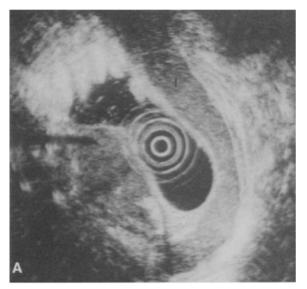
(A) Endosonogram reveals a hypoechoic submucosal wall infiltration (t) in the fundus of the stomach, which shows a continuity with a hypoechoic pancreatic tail tumor. The gastric wall adjacent to the liver (l) and spleen (s) shows no abnormalities (big arrows) in contrast to those of infiltrated area. Note the position of the needle as a echogenic spot (n) with dorsal shadowing. Olympus XJF-UM3 (frequency 7.5 MHz). (B) CT scan shows a circumscribed thickening of the fundus wall (t) located adjacent to the spleen (s) and aorta (ao) suspicious of submucosal lesion. Note the close relationship between the submucosal lesion and the spleen. c = gastric lumen filled with contrast, l = liver.
